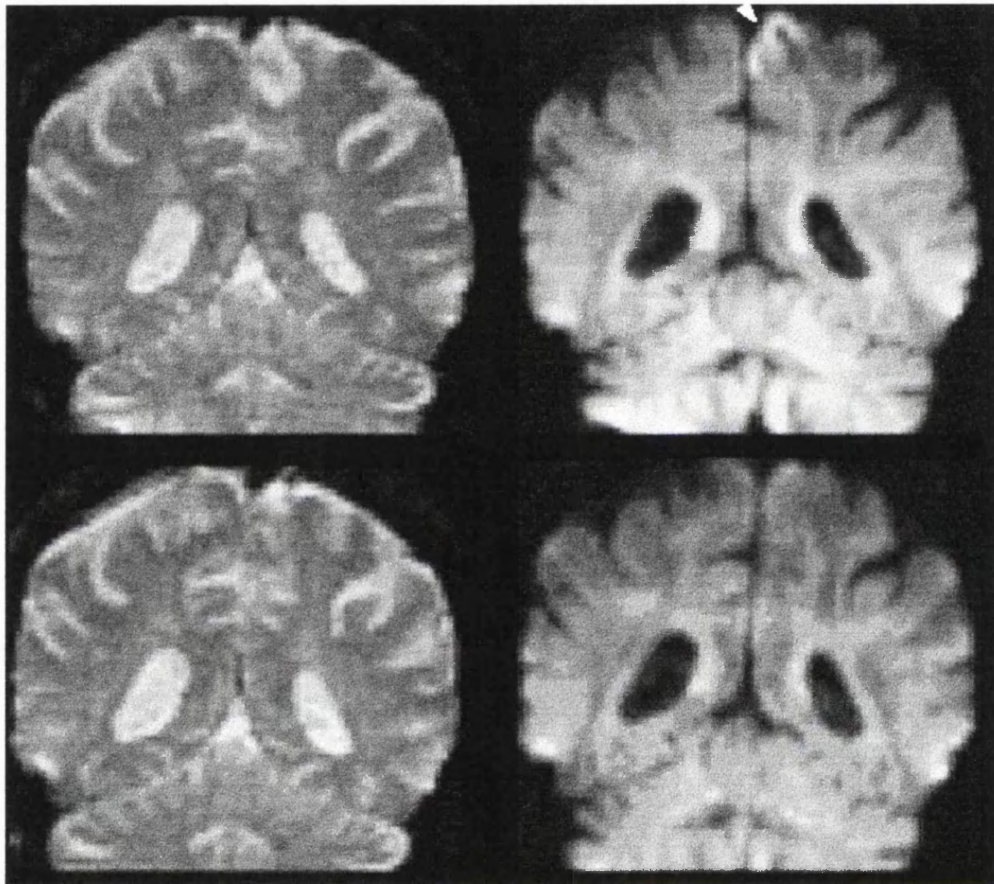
DWI during and after status. The status affected the right leg (left on images is patient's right). Top left: T2-weighted images during status. Top right: DWI during status. Bottom left: T2-weighted image after status. Bottom right: DWI after status. On DWI during status a high signal in the motor cortex of the right leg (indicating a decreased diffusion, arrow head) and a low signal in the subcortical white matter (indicating an increased diffusion) is visible. Both changes resolved after status.
